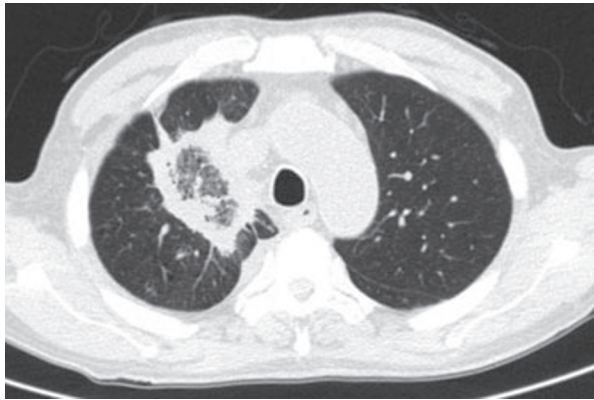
Computed tomography in mucormycosis revealing a reversed halo sign, also known as inverted halo or atoll sign.
